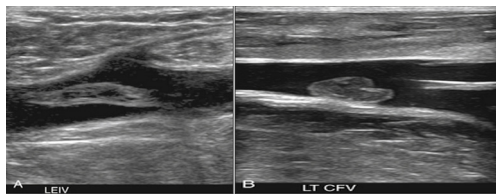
Free floating thrombus in deep veins, rises the alert to avoid using compression technique to assess for patency of the vein. Color Doppler filling should be used instead of direct compression by the probe since there is a risk of dislodging part of the thrombus causing emboli and PE as consequence.
